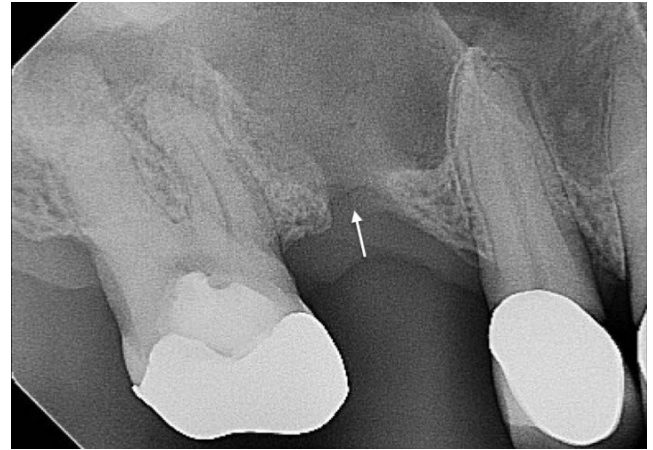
Periapical radiograph of a 73-year-old man. Note the loss of cortical plate in the extraction site of the right maxillary first molar (white arrow).
